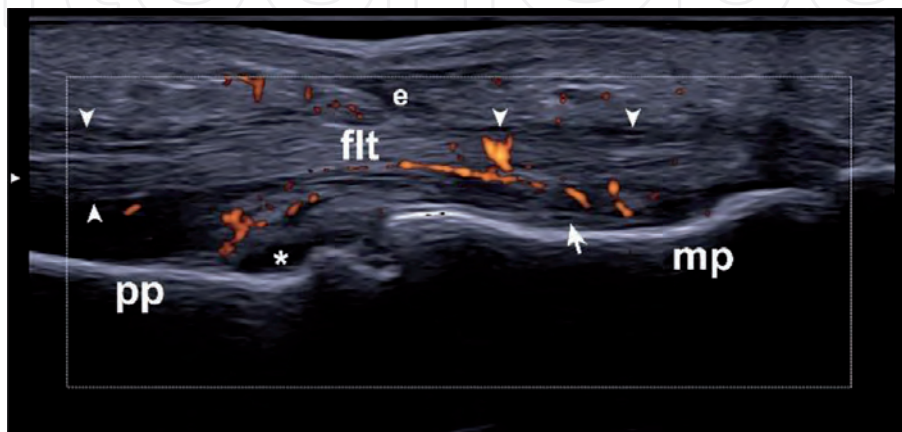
Ultrasound image of a volar aspect of the finger, showing changes specific to dactylitis. pp – Proximal phalanx, mp – Medial phalanx, flt – Flexor tendon, asterisk – Synovitis, e – soft tissue oedema, arrow – enthesitis of the superficial flexor tendon, arrowheads – Flexor tenosynovitis.
